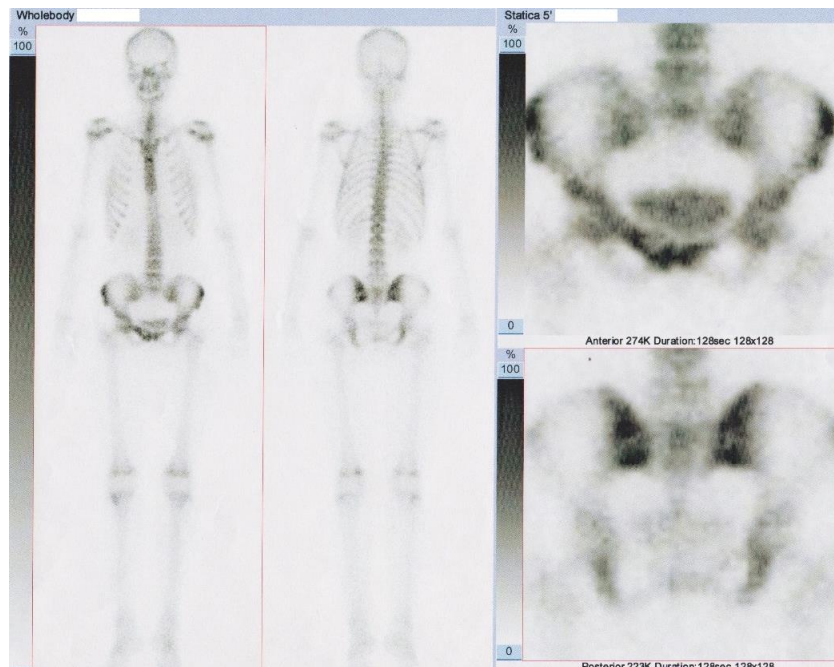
Technetium 99m-MDP bone scintigraphy showing increased fixation of the radioisotope in the superior right pubic ramus area
